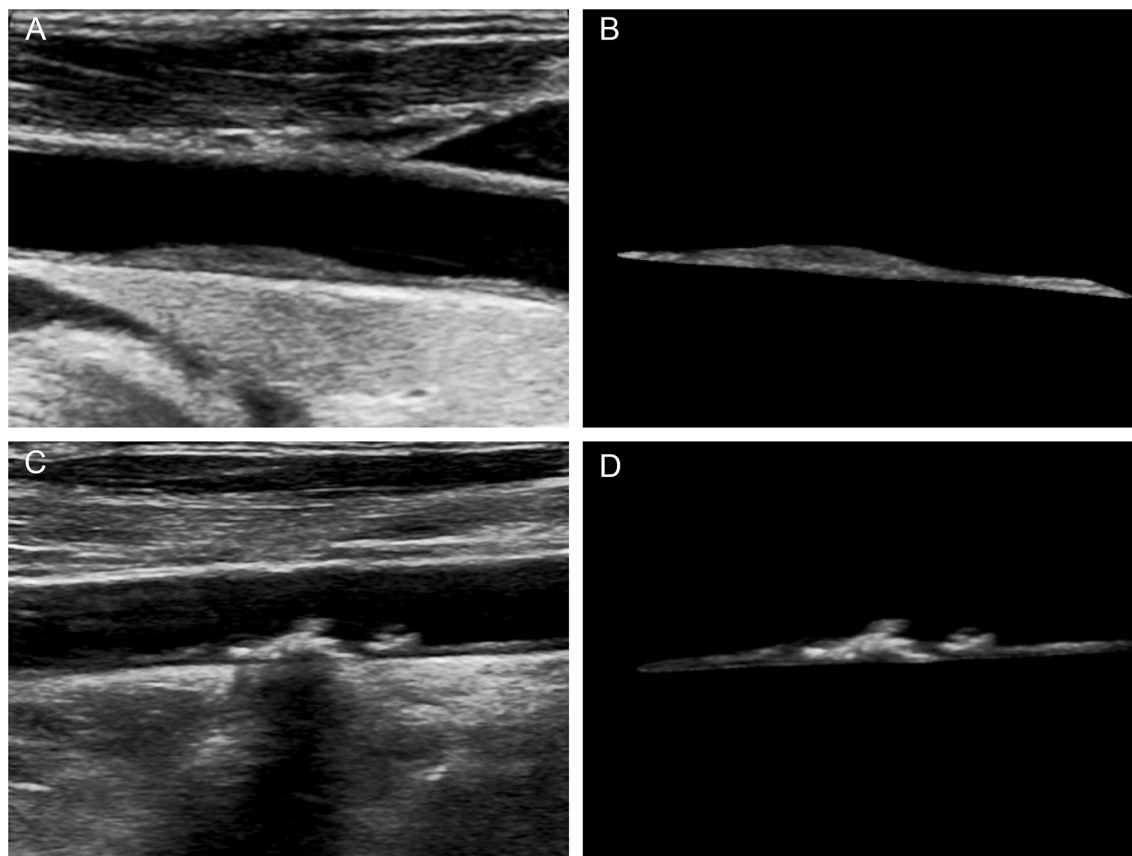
Vulnerable and stable plaques in carotid ultrasound images before and after artificial intelligence segmentation. A: Stable plaques in ultrasound images; B: Artificial intelligence-segmented stable plaques; C: Vulnerable plaques in ultrasound images; D: Artificial intelligence-segmented vulnerable plaques
